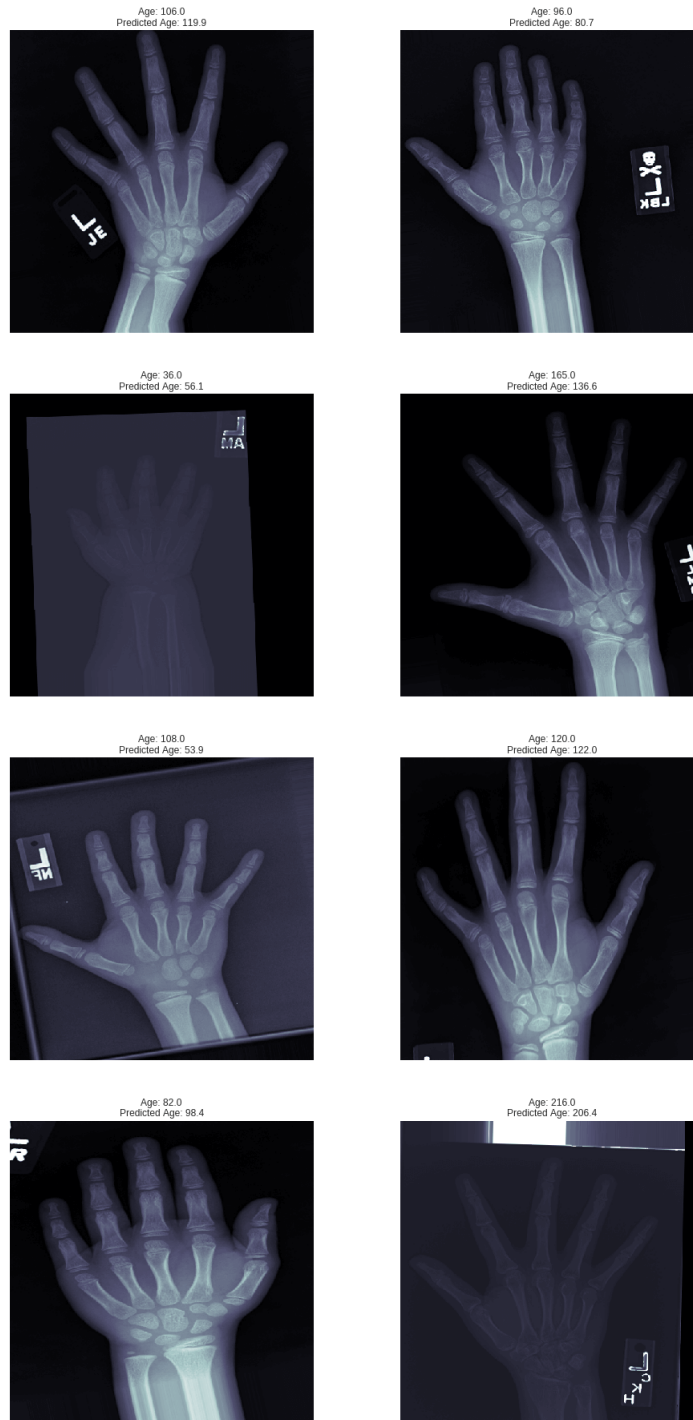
Examples of comparison predicted bone ages with its real bone ages of the radiographs by adopting MobileNet weights on validation set.
